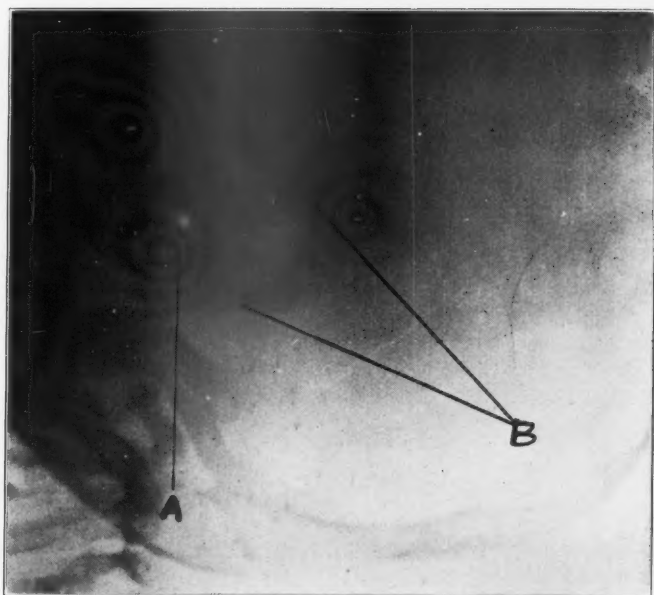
Roentgenogram of normal mastoid in child 7½ months of age.
